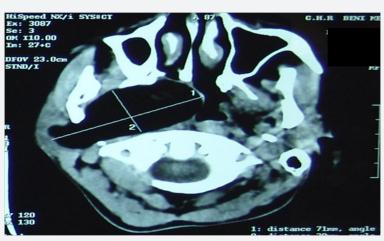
An axial image from the CT scan shows a large parapharyngeal mass of fat density measured 71 x 45 mm.
